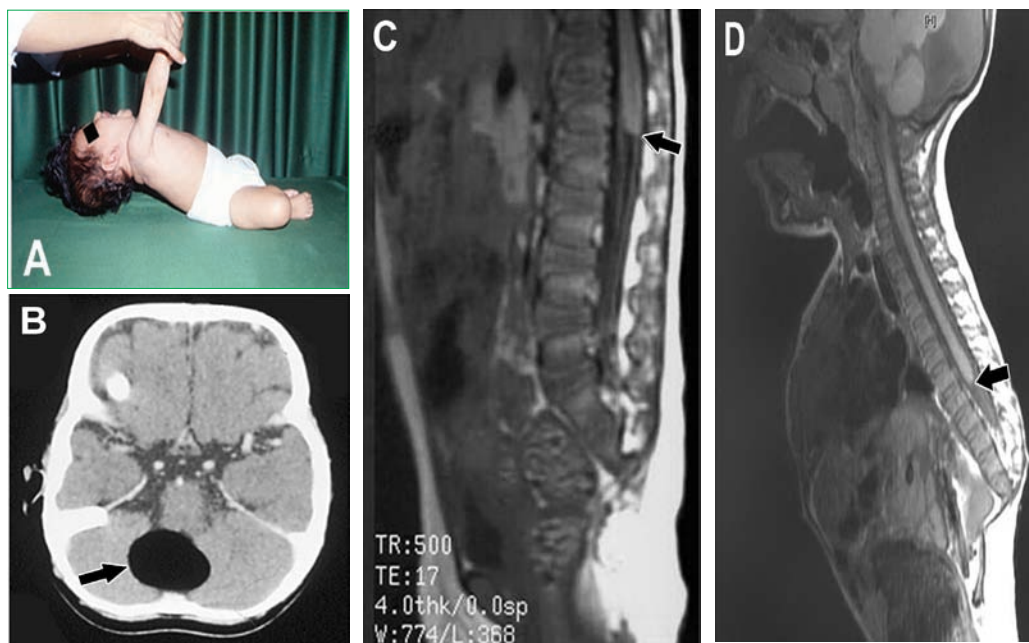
Images showing: A & B) thoracic and cervicocephalic intramedullary lipoma: A) the affected 9-month-old presented as floppy infant syndrome. Spinal CT scans showed an expanded cervicothoracic spinal cord filled by a large low-density mass (image not shown); B) cranial CT revealed extension of the low-density mass (lipoma) in the posterior fossa (arrow); C & D) Caudal agenesis. C) sagittal T1-weighted (T1W) MRI image showing the less severe form, with blunted appearance of the distal cord (arrow) and dysplastic sacrum; and D) sagittal T1W MRI revealing severe caudal agenesis. There is also blunted appearance of the distal spinal cord (arrow).
